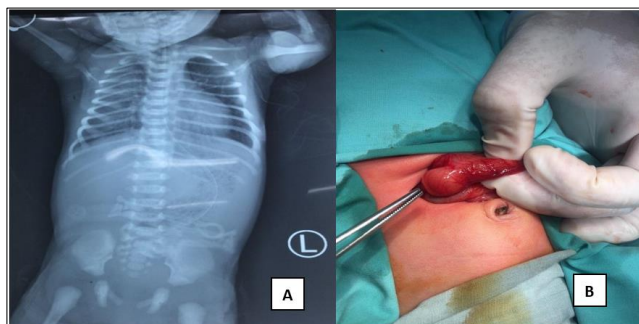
A) Single, large air bubble on plain x-ray, B) Showing hypertrophied pylorus.
